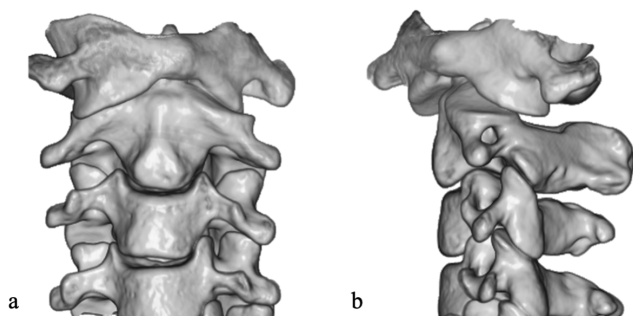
1B. Three-dimensional computed tomography of case 1 shows adult atlantoaxial rotatory fixation of Fielding type 1.
